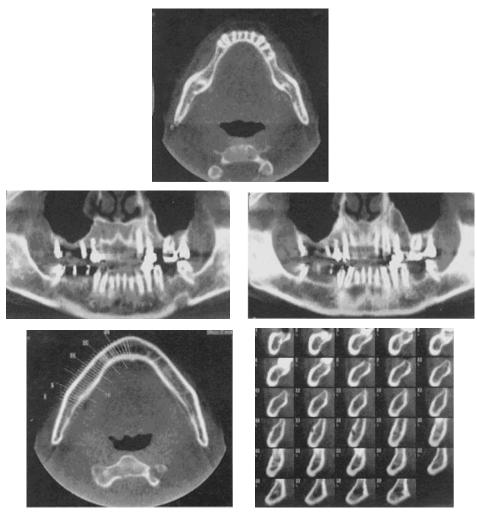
Axial, paraxial, and cross-sectional images on CT.
